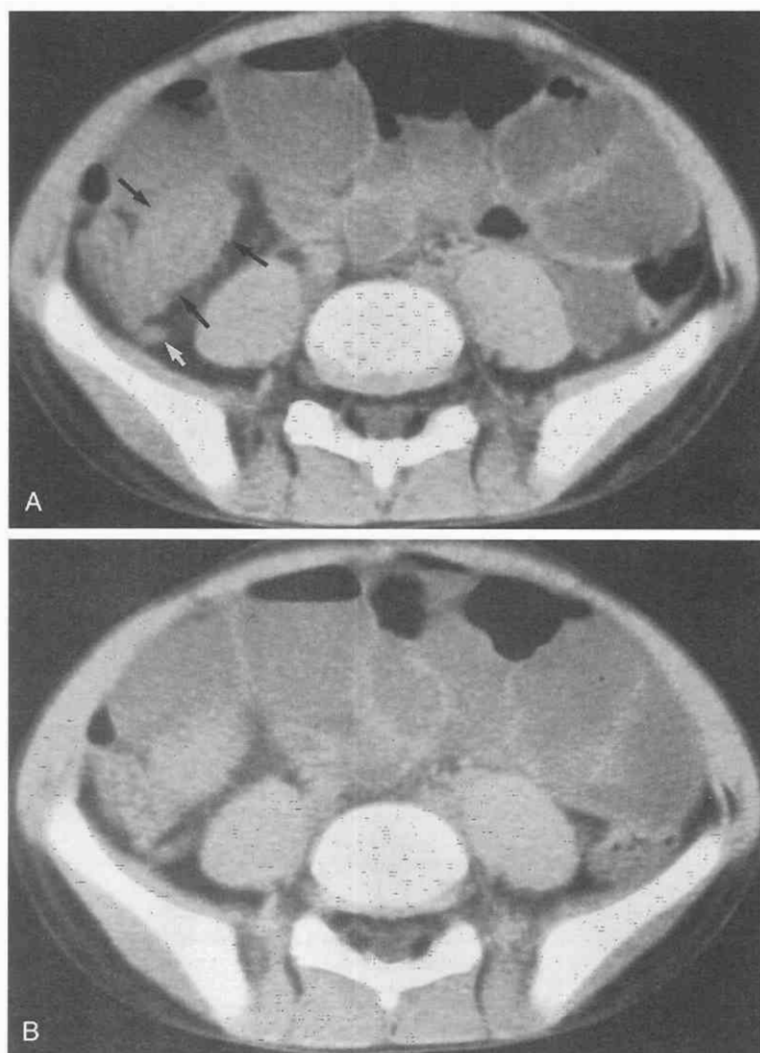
Low-dose CT scanning in an 8-year-old boy seen in the emergency department for possible appendicitis. A, Axial CT scan obtained through the pelvis without oral or intravenous contrast material was obtained initially at 100 mA. These are multiple fluid-filled loops of small bowel in addition to thickening of the terminal ileum (arrow) due to Crohn's disease. The appendix (small arrow) was normal. B, Subsequent CT images were obtained through the pelvis because an artifact was present in the initial series. The image from a level similar to that in A but obtained at 30 mA shows no substantial difference in diagnostic information. (Courtesy of Ithaca Center for Postgraduate Medical Education, Ithaca, NY, 2001.)
